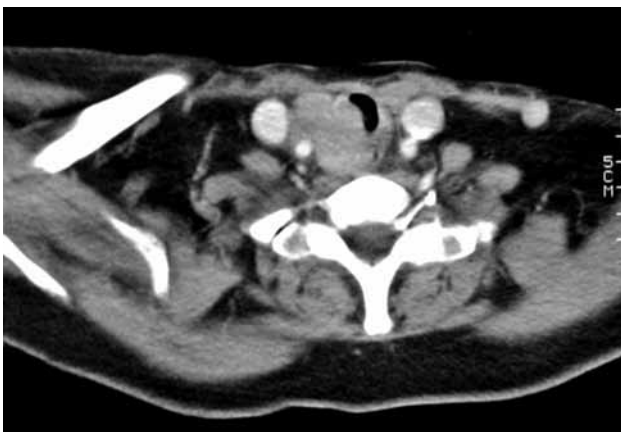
Contrast enhanced computed tomography section at the level of first thoracic vertebrae, showing right laryngotracheal airway invasion by papillary thyroid carcinoma.
